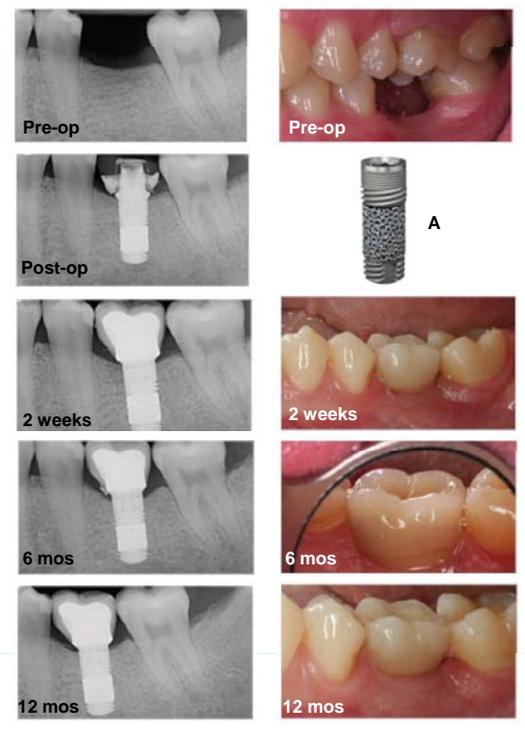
The study device (A) included a porous tantalum midsection supported by a threaded titanium body. Radiographs (left) and clinical views (right) of a female patient in the IL study presented with a healed edentulous space in the mandibular left first molar area (pre-op) for placement and immediate provisionalization (post-op) of a TM dental implant (4.7mmD x 10mmL). After two weeks of soft tissue healing, sutures were removed and the definitive restoration was delivered. The fully functional implant maintained soft tissue levels and exhibited no complications 6 months after implant placement. One year after placement, the implant was stable and fully functional with minimal (0.19 mm) crestal bone loss. (Case contributed by Dr. Markus Schlee)
